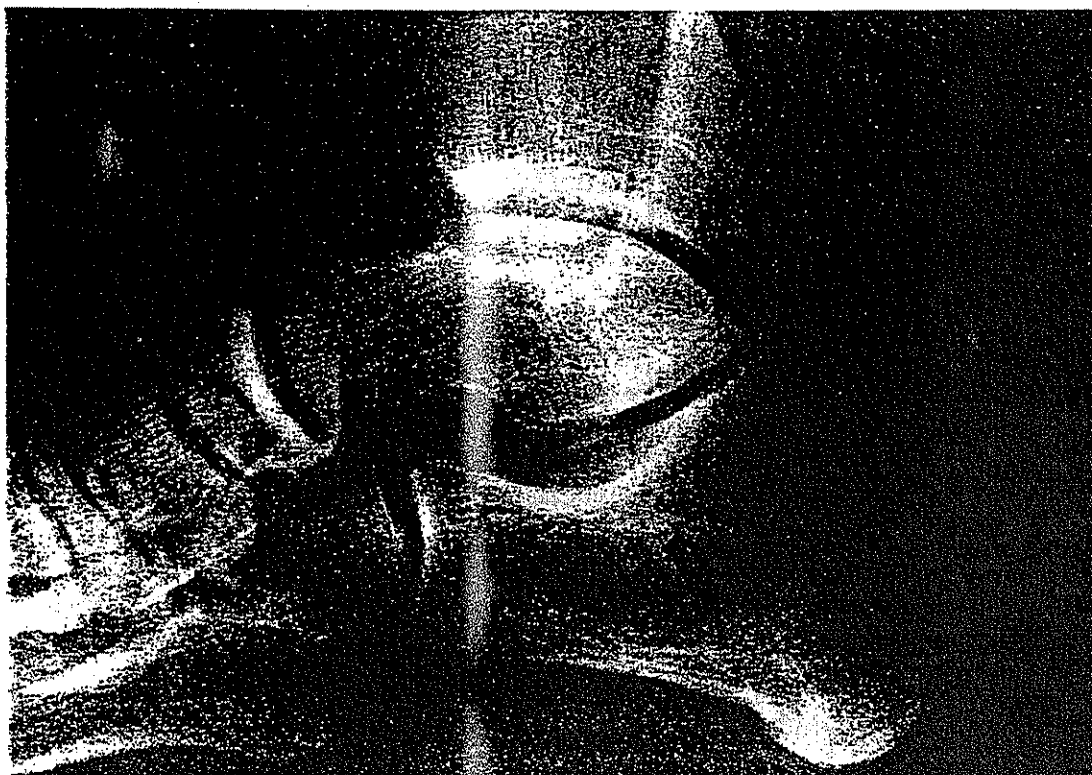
Lateral roentgenogram of a clubfoot showing posterior slanting of the articulating surface of the tibia. The sphericity of the talar dome is diminished. The subtalar joint is markedly abnormal with continuous posterior and middle facets. There are no demonstrable anterior facets. The sinus tarsi is wide and the head of the talus is small.
